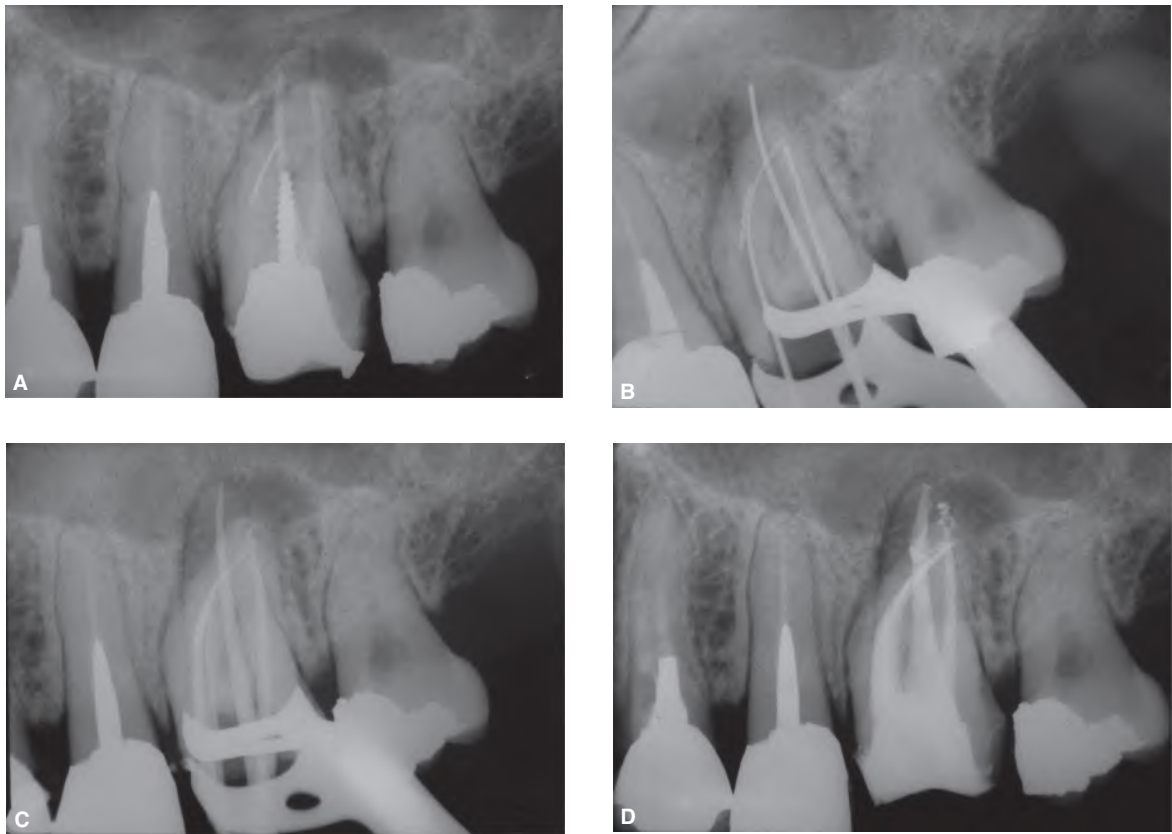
A. Preoperative radiograph of the first molar showing a separated instrument located beyond the curvature of the mesial root. B. After radicular access to the head of the fragment, the instrument could be bypassed with small hand files. C. During cleaning and shaping, the fragment was floated out with irrigation. Cone fit radiograph showing instrument removed. D. Postoperative radiograph showing canal obturation.
